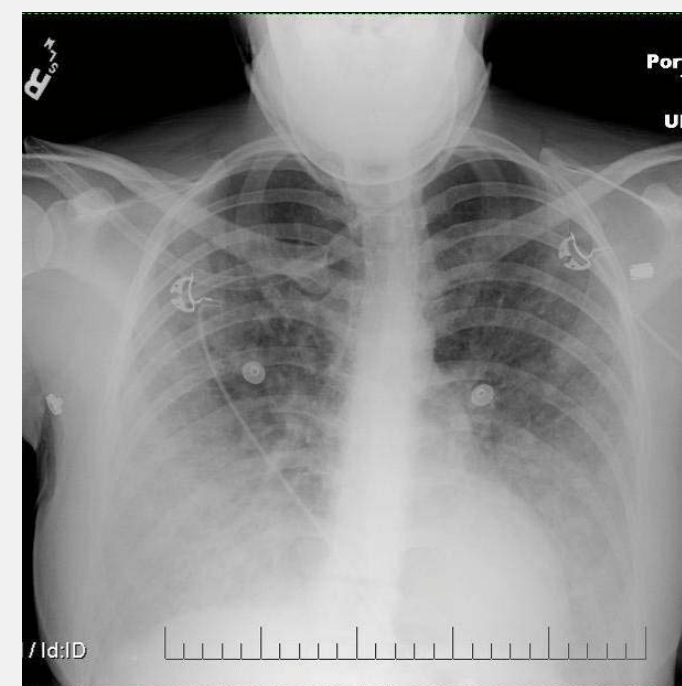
Chest x-ray of 35 year old healthy female who developed dyspnea and hemoptysis after approximately 200 m into open-water swim. Patient was admitted to the ICU with SpO₂ of 55%. X-ray is consistent with IPE. Pulmonary edema resolved with diuresis. LV function and valves were normal and investigations for coronary disease were negative
